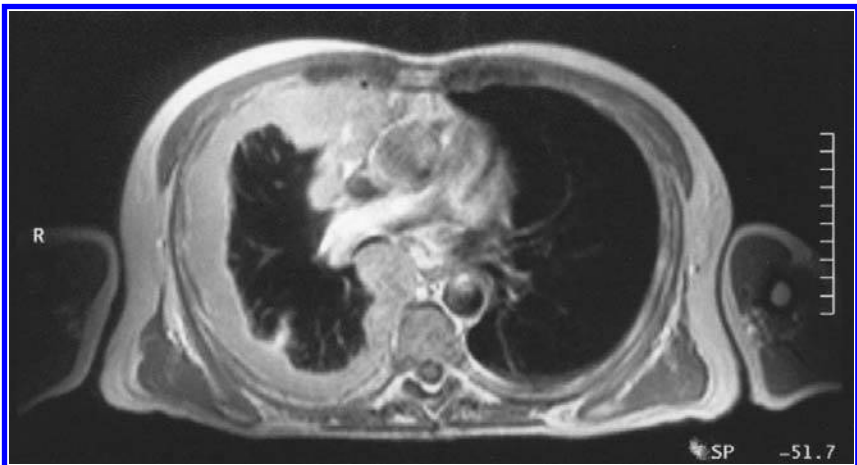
MRI axial image on a patient with malignant pleural mesothelioma.
